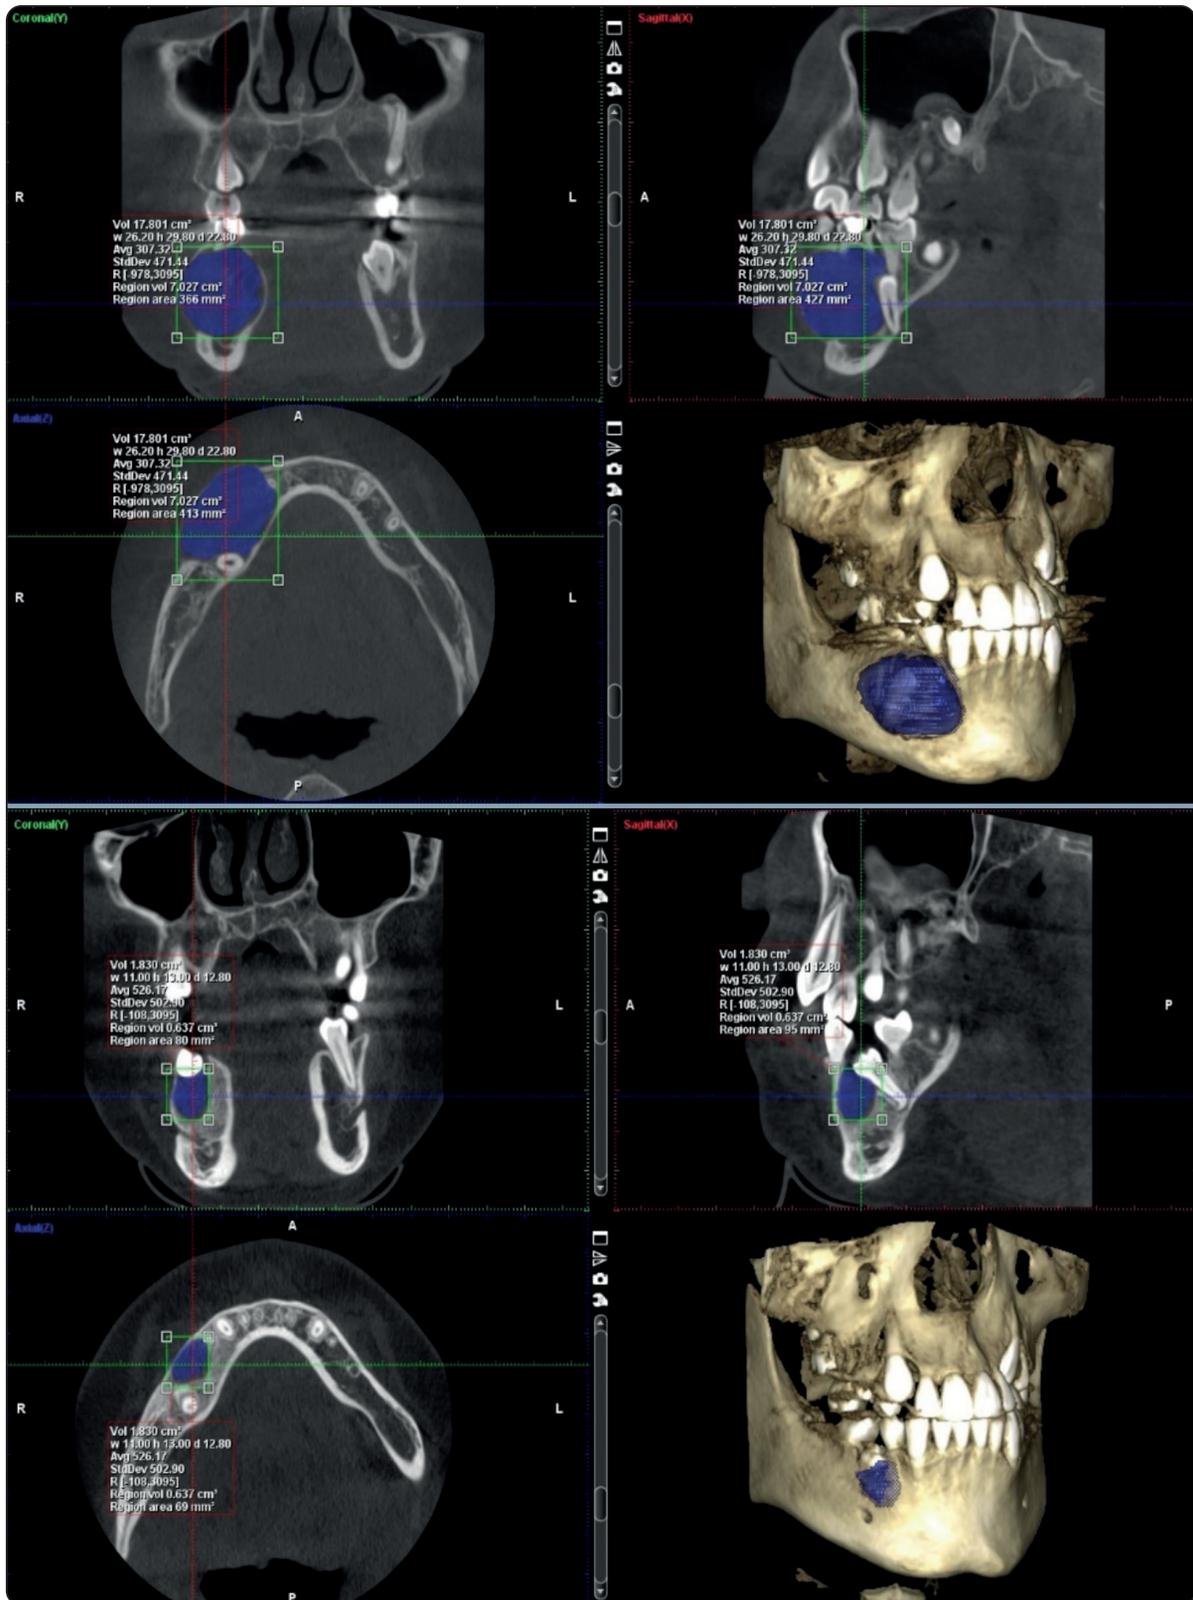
Preoperative and 6 month postoperative CBCT of dentigerous cyst for 3D volumetric comparison
